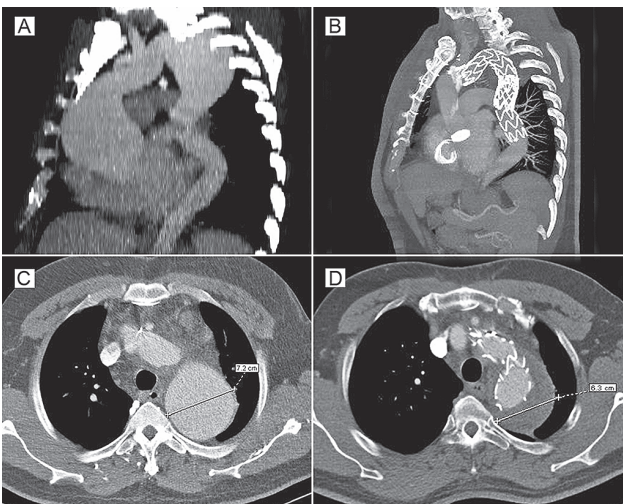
(A) A preoperative CT scan reconstruction (sagittal plane) showing extensive aneurysms of the ascending and descending aorta. (B) A CT scan reconstruction (sagittal plane) 6 months after distal endovascular extension of implanted stentgraft showing an optimal position of „elephant trunk“, and two distally placed stentgrafts, without evidence of endoleak. (C) A preoperative CT scan (transverse plane) demonstrating a giant aneurysm of the descending aorta, maximal diameter of 72 mm. (D) A CT scan (transverse plane) 6 months after distal endovascular extension of implanted stentgraft demonstrating a completely thrombosed aneurysm of the descending aorta.
